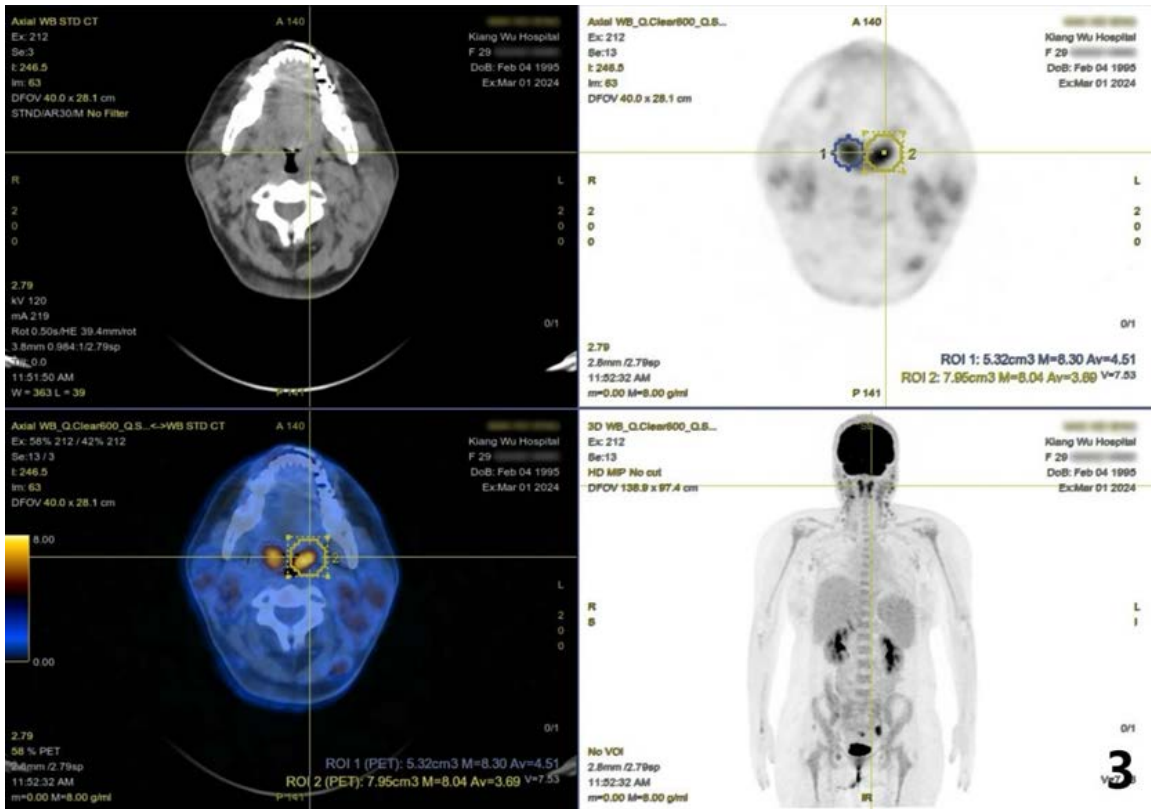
A 29-year-old woman with BPDCN underwent an 18F-FDG PET/CT examination. Bilateral tonsillar enlargement with increased metabolism was observed, with SUVmax values of 8.3 on the right and 8.0 on the left.
